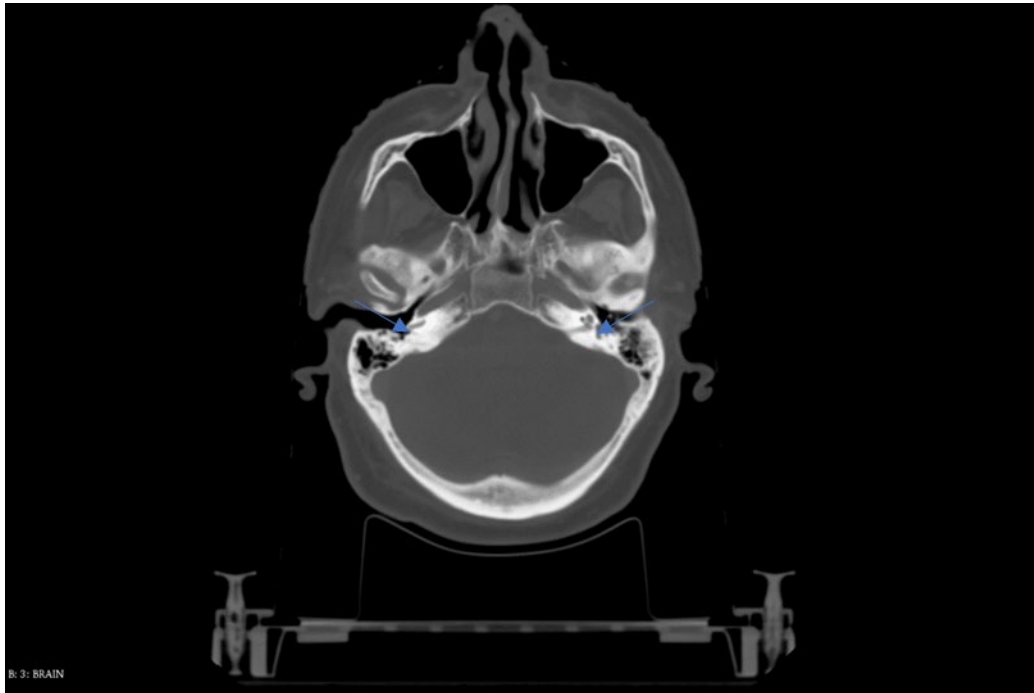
Clinical CT resolution of the brain. The arrows indicate the right and left cochlea.
